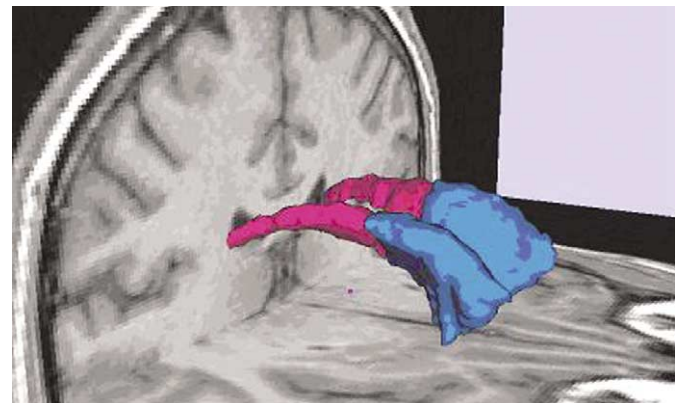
A Three-dimensional rendering of left and right head of the caudate nucleus (shaded blue) and left and right posterior caudate nucleus (shaded red) superimposed on magnetic resonance imaging coronal and axial slices in a normal subject. Adapted from Levitt et al (2002).
